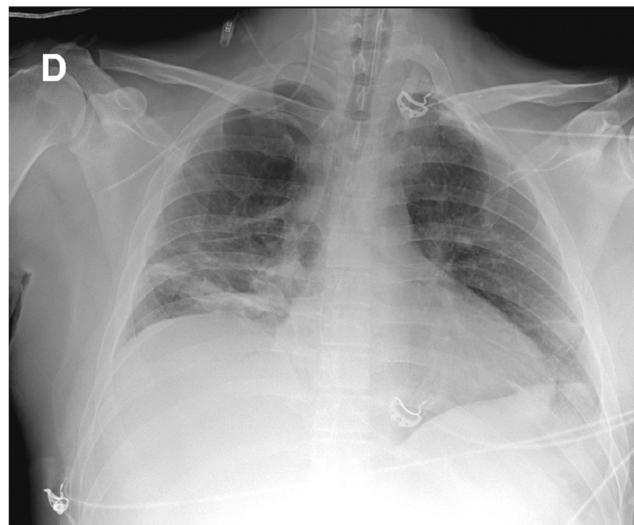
Chest radiography taken shortly after the endotracheal tube insertion in the emergency department. It shows a parenchymal condensation in the right lower lobe.
